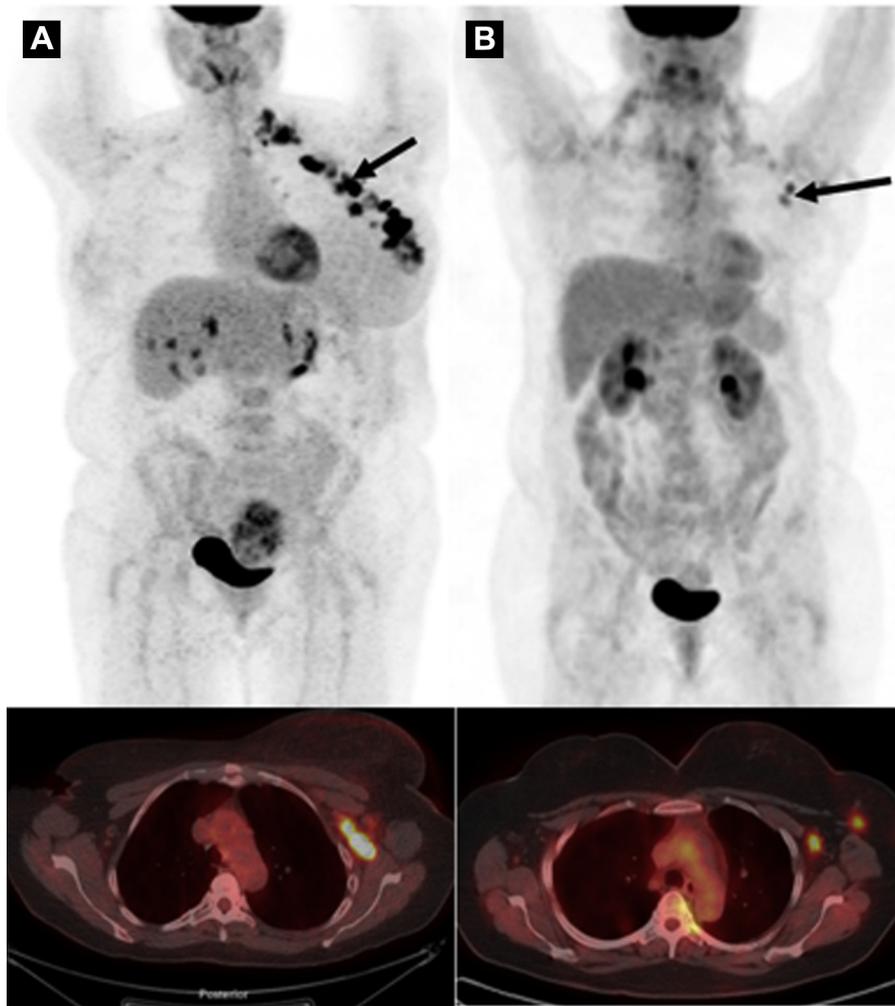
Abbreviations: CT = computed tomography; FDG = fluorine-18 fluorodeoxyglucose; pCR = complete pathologic response; PET = positron emission tomography; PMRT = post-mastectomy radiation therapy; SUVmax = maximum standardized uptake value; TN = triple negative.
